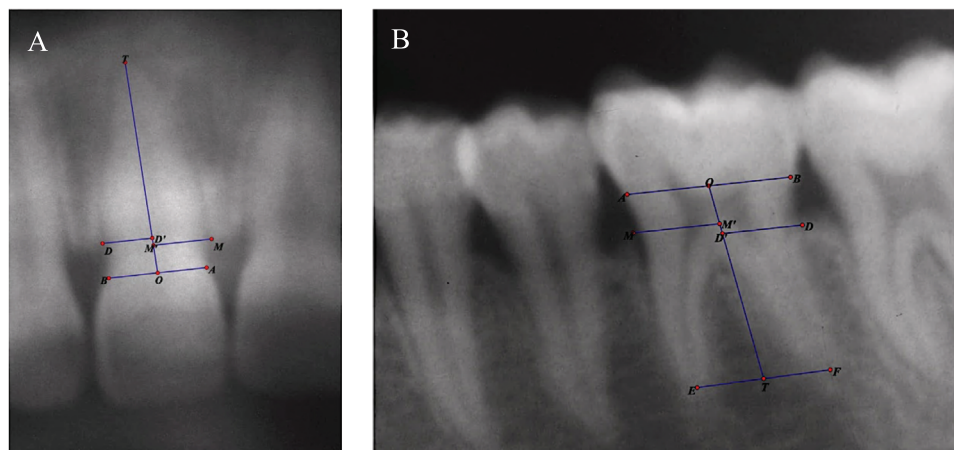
Measurement on anterior (A) and posterior (B) teeth on panoramic radiographs. The midpoint of the cemento-enamel junction (CEJ) line was considered as point O, and the apex of the root was marked as point T. OT represented the root length (RL). The lowest point of mesial (distal) alveolar bone was marked as point M (D). Being projected to the RL which was parallel to the CEJ line, point M (D) was then transferred to and intersected at the RL as point M' (D'). M'T (D'T) represented the mesial (distal) alveolar bone height (ABH)
